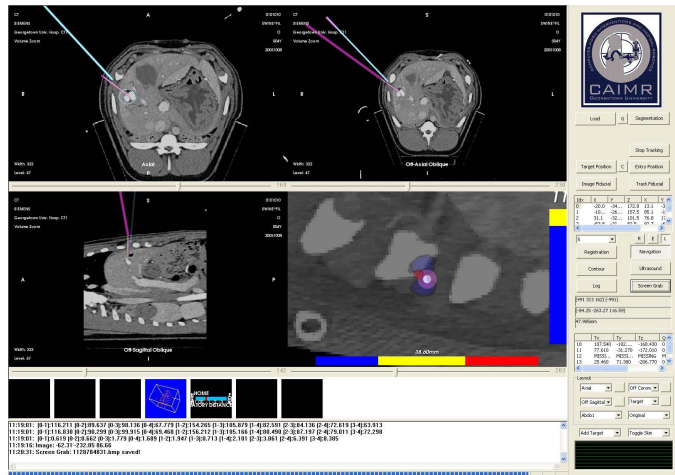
Graphical user interface for an electromagnetically guided interventional radiology system. By registering the tracker space to a pre-acquired CT image, the position and orientation of tools such as needles and catheters can be measured in real time and overlaid on the image
